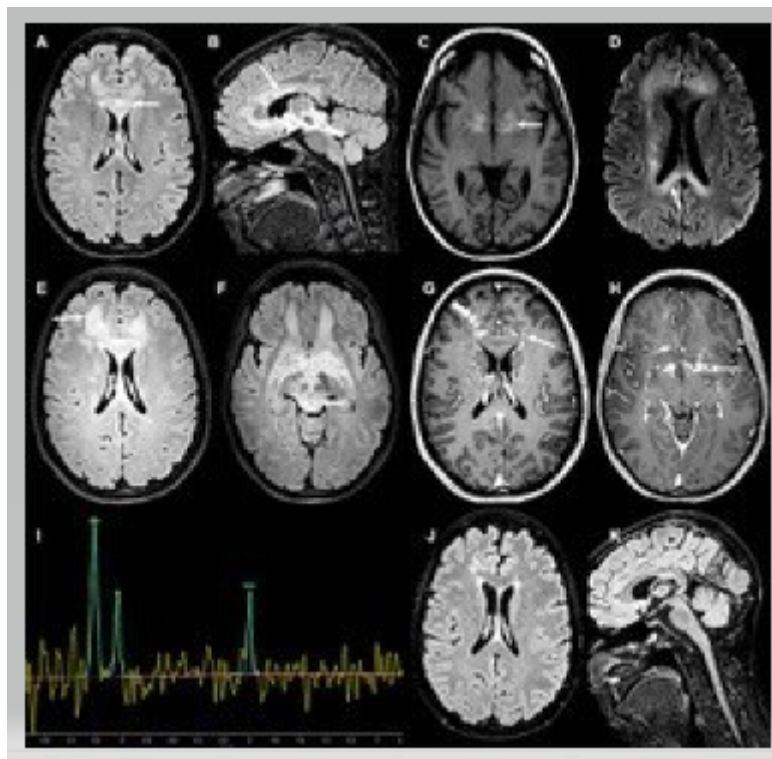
Serial MRI of HSV-7 encephalitis following Obinutuzumab-CHOP treatment.
